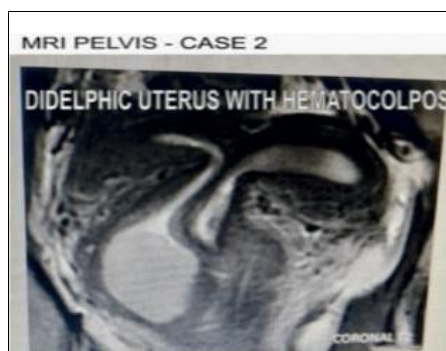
MRI showing didelphic uterus with hematocolpos in right side
